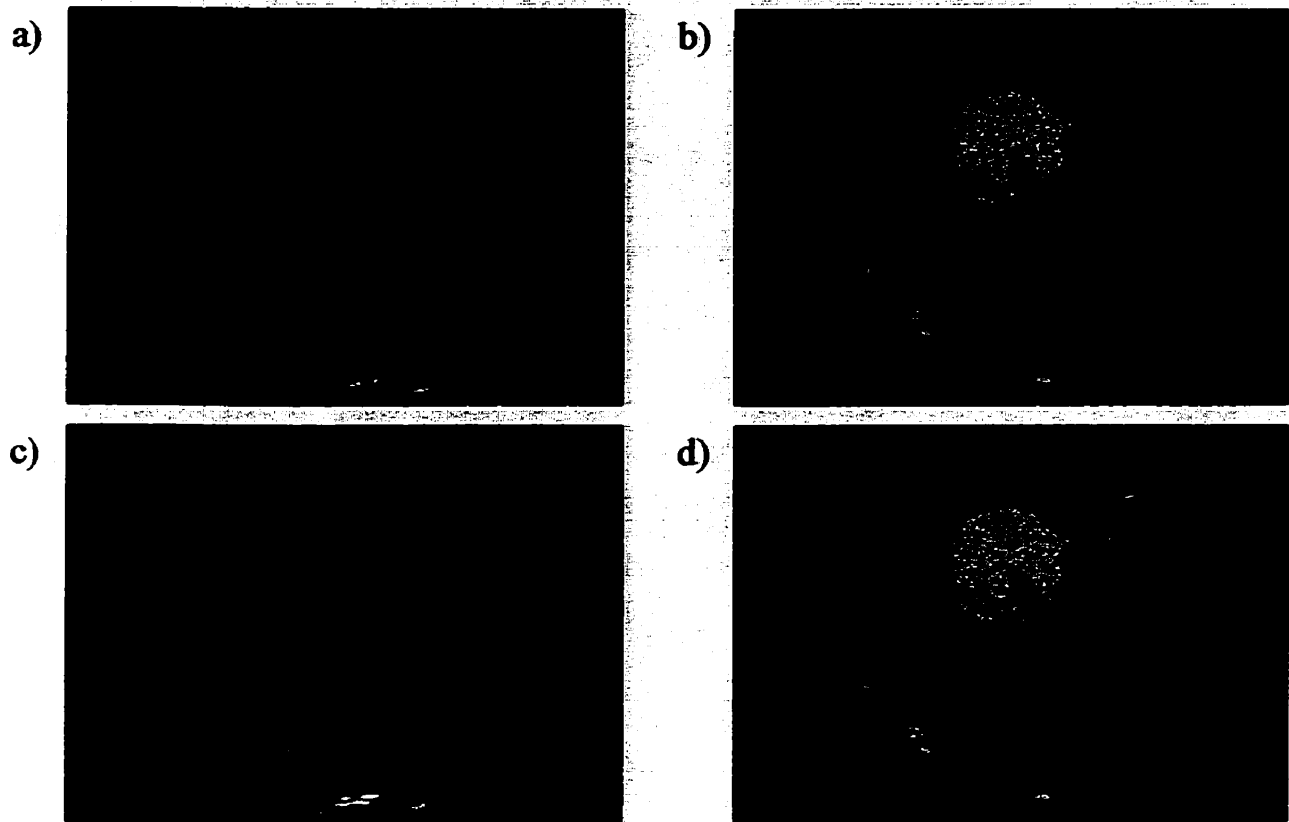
Apical 4 chamber views of the heart made with 4-pulse pulse inversion Doppler imaging ($MI=0.1$) using a conventional power threshold to identify microbubbles: a) baseline; b) following a bolus injection of Definity ($18 \mu\text{l}/\text{kg}$). These same data were reprocessed using an experimental thresholding technique, showing similar contrast enhancement with reduced Doppler artifacts in the baseline image (Figures c and d) (Hope Simpson and Burns 2000).
